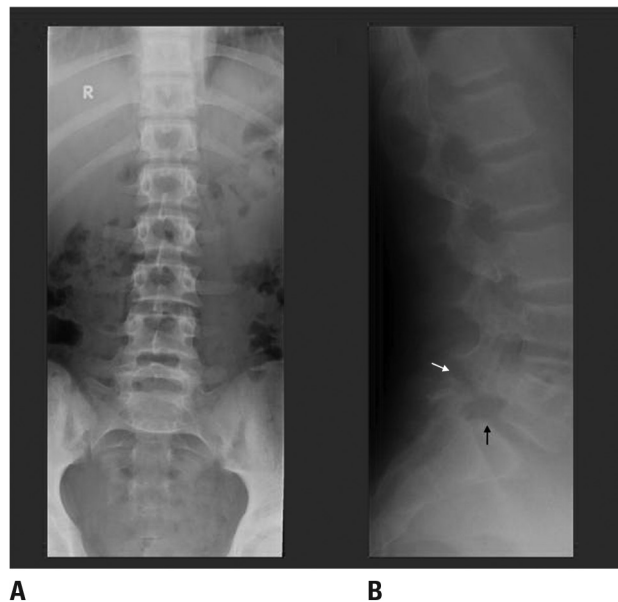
Radiographic findings in a patient with L5 pars interarticularis fracture and mild L5 on S1 spondylolisthesis: anteroposterior (A) and lateral (B) images. (White arrow points to the fracture and black arrow points to spondylolisthesis of L5 on S1.)
